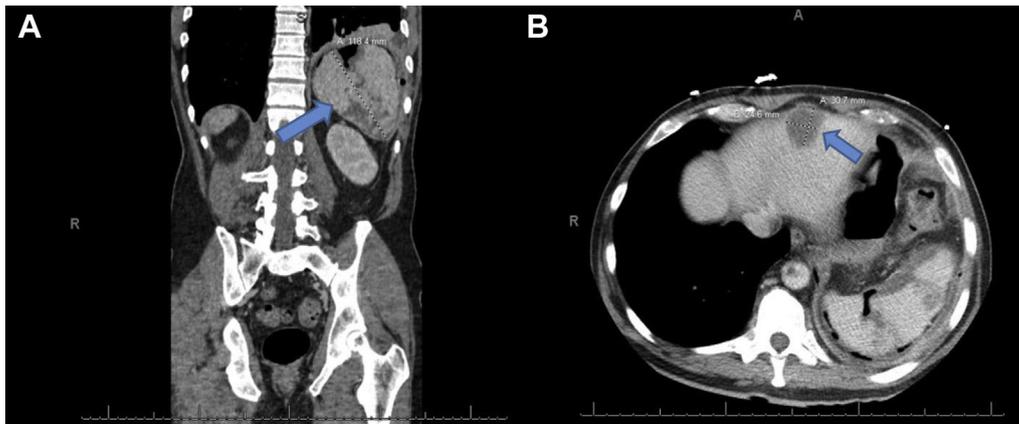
Preoperative computed tomography scans showing large splenic (A) and intrahepatic (B) abscesses.
